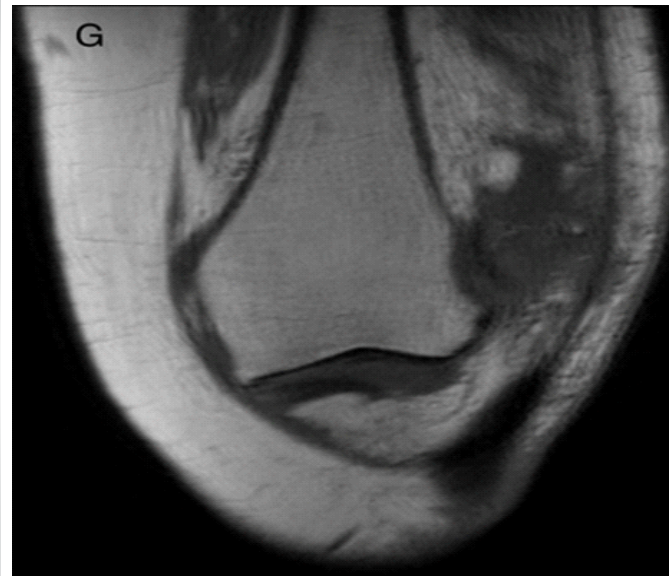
Coronal cut of magnetic resonance imaging of the left knee with lateral patella dislocation, with notable lateral femoral condyle impaction injury.
